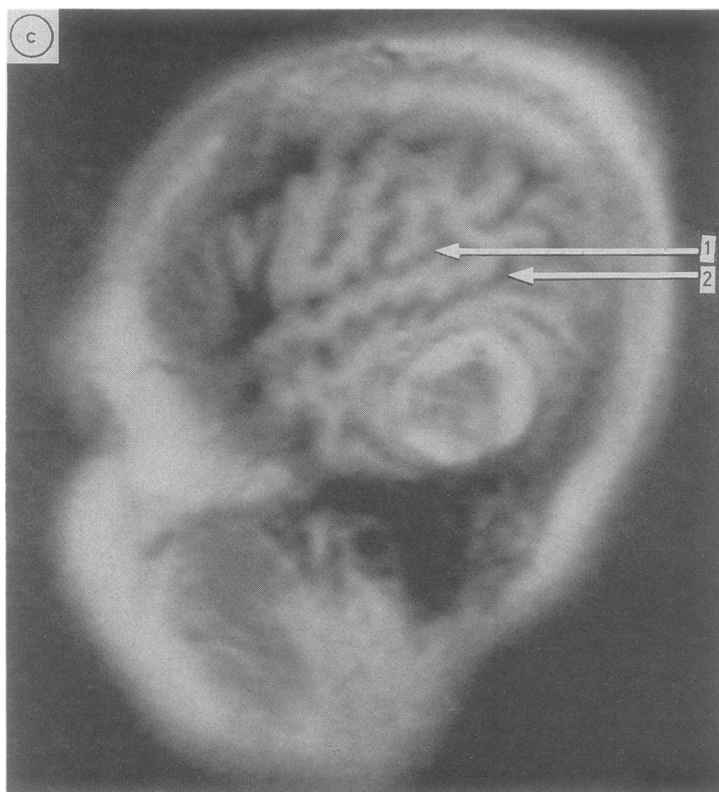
MRI (55 days after symptom onset) (inversion recovery technique). (a) Horizontal view [time of repetition (TR) 2080 ms, time of inversion (TI) 500 ms], (b) Coronal view (TR 1500 ms, TI 500 ms), (c) Left lateral sagittal view (60 mm from midline) TR 2080 ms, TI 500 ms). All MRI showed a ring-like high intensity area involving the cortex and the subcortical white matter of the posterior part in the left inferior temporal gyrus, (1) lateral cerebral fissure, (2) superior temporal sulcus.
